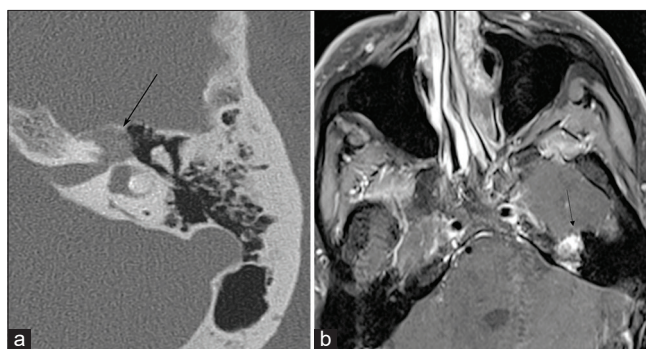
A 50-year-old man with facial nerve hemangioma. (a) Axial high-resolution computed tomography image shows characteristic stippled calcification in the region of the left geniculate ganglion (arrow) (b) post-contrast axial T1 fat-suppressed image reveals focal enhancement in the same region (arrow).
